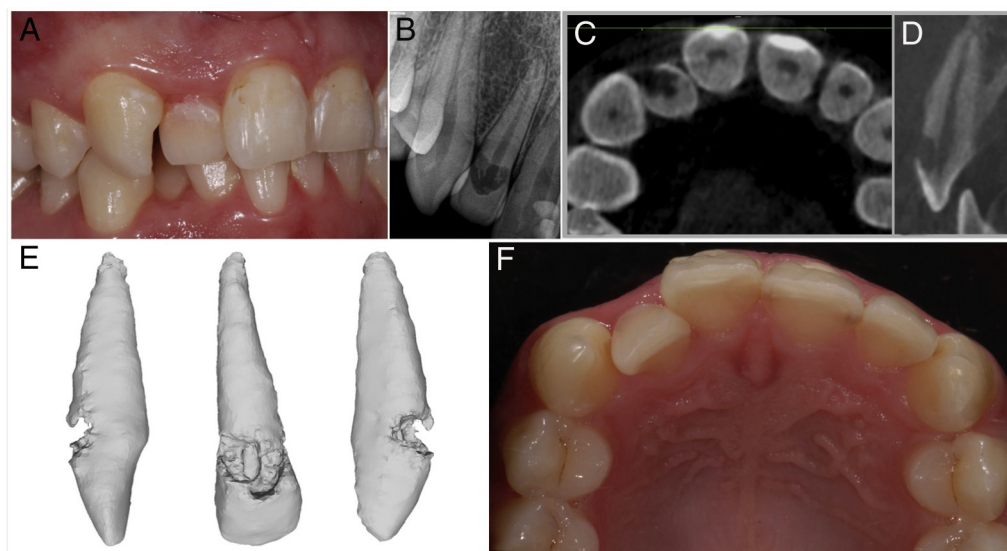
(A) At inspection, a reddish lesion was seen at the cervical area of tooth #7, compatible with ICR. (B) The initial periapical radiograph. A large radiolucent area with well-delimited borders at the cervical region of tooth #7 was observed. The root canal walls appeared preserved. (C) Transversal and (D) sagittal views of the resorptive lesion in CBCT imaging. The lesion was very close to the pulp canal, but it was not surrounding it yet. No or little extension toward the root dentin was observed. (E) A 3D digitalized image of the resorbed tooth was generated from CBCT imaging. The real extent of the lesion was visible. The predentin layer protecting the pulp was not visible because of its minimal thickness, and the pulp seemed exposed although it indeed was not. (F) Tooth #7 was palatally positioned regarding teeth #8 and #6. The palatal position interferes with the access to the cervical lesion. Orthodontic treatment was needed to correct malocclusion and, at the same time, to improve access to the resorptive lesion.
